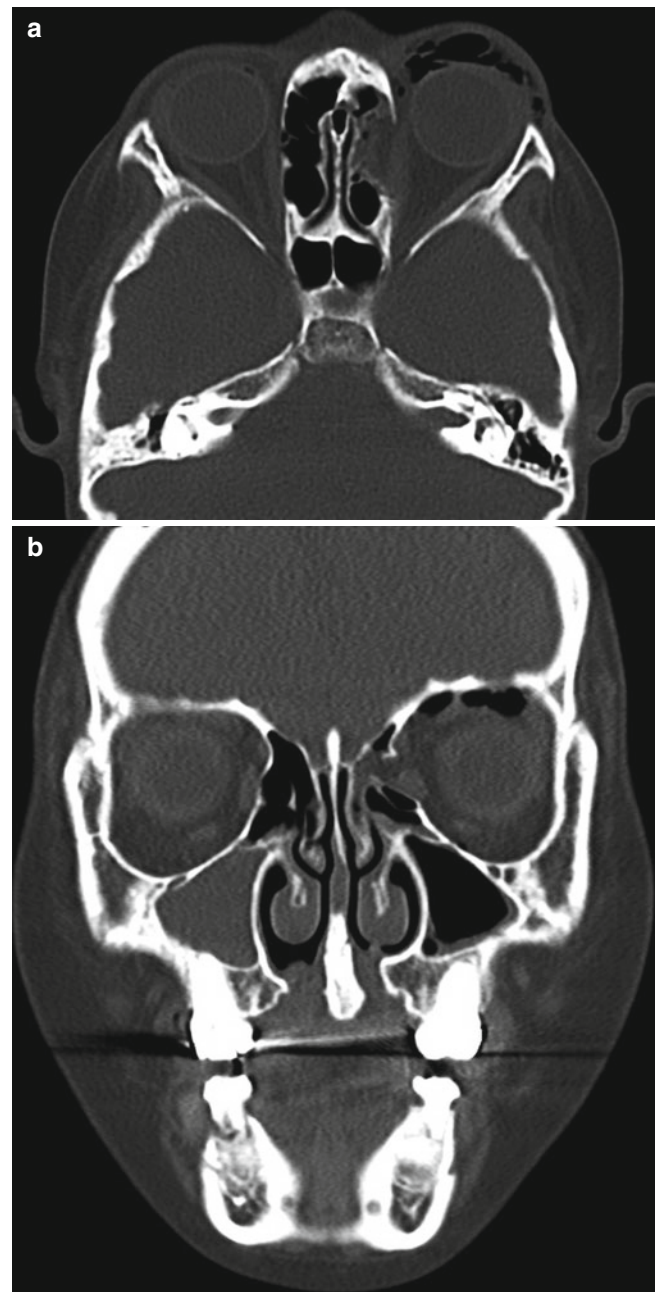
Medial orbital blowout fracture. (a, b) Axial (a) and coronal (b) facial bone CT scans show a large defect in the medial wall of the left orbit with orbital fat herniation. There seems to be encroachment of the medial rectus muscle, which is asymmetrically thickened due to edema. Periorbital emphysema is associated. Right maxillary sinus opacification is an incidental finding
